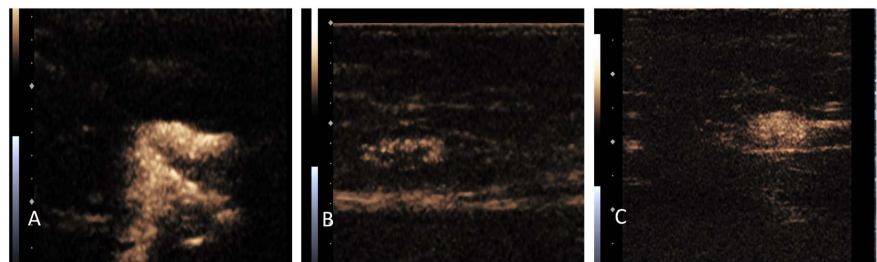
Transcutaneous injection of ultrasound contrast agent to locate anterior sentinel lymph nodes along the lymphatic vessels. (A) A central filling defect is seen (pathology with metastasis); (B) Homogeneous circumferential hyperenhancement (pathology without metastasis); (C) Homogeneous hyperenhancement is seen pathology without metastasis).
